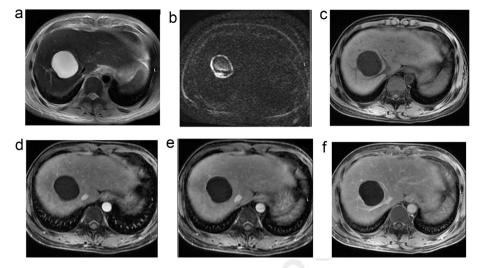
Abdominal MR showed hypointense on T1WI (C) and hyperintense on T2WI (A). The wall of the abscess is peripherally enhanced (D-F). On the diffusion weighted imaging (DWI) (B), the lesion was restricted diffusion.
